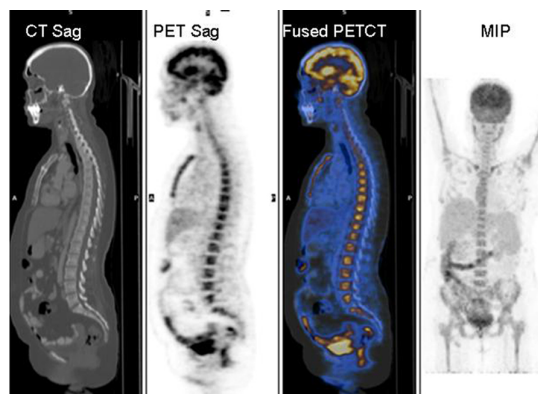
Sagittal section of ¹⁸F-FDG PET-CT showing heterogeneous increased ¹⁸F-FDG uptake in bone marrow (SUV Max 6.7).
